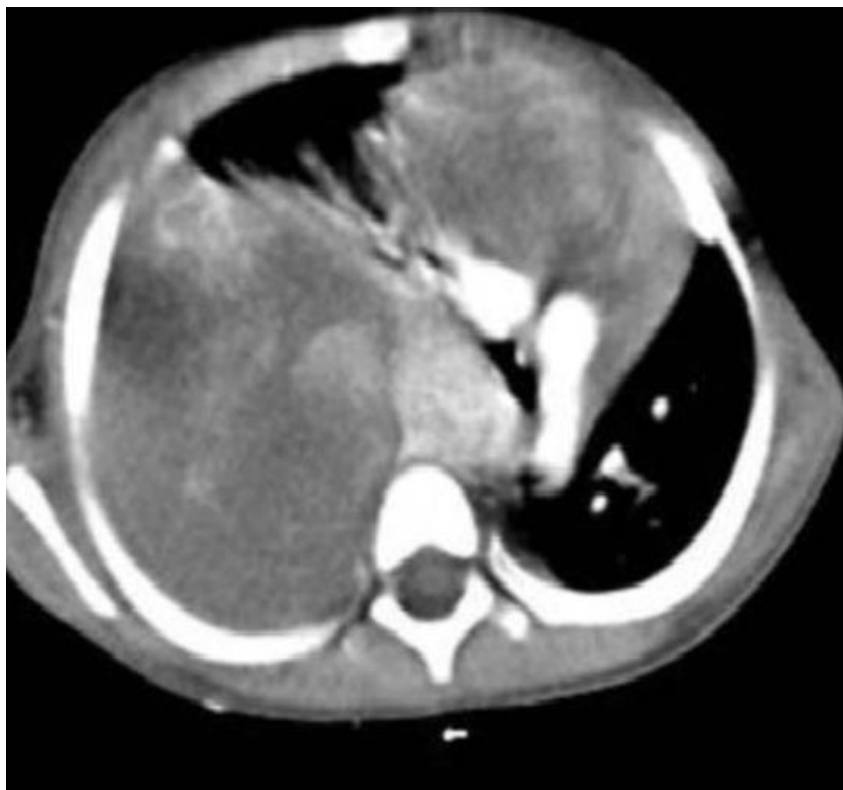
Contrast-enhanced computed tomography of the chest showing right upper mediastinal mass which was compressing the SVC and collateral vessels
